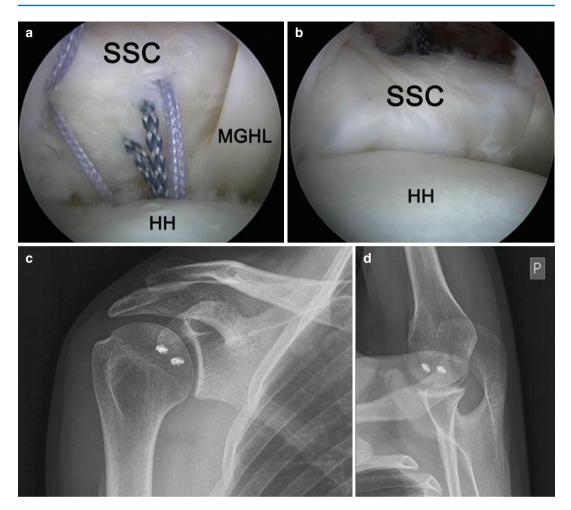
Arthroscopic McLaughlin procedure (a, b). Postoperative anteroposterior (c) and Bernageau (d) radiographic views
